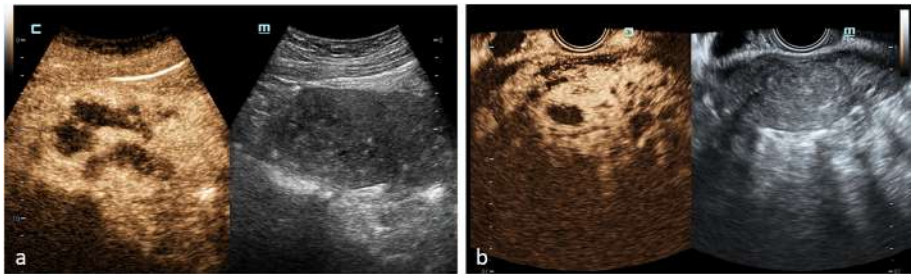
Images from postoperative ultrasound venography. (a) Image taken 5 months after the PUSH Approach. (b) Image taken 8 months after the PUSH Approach.
